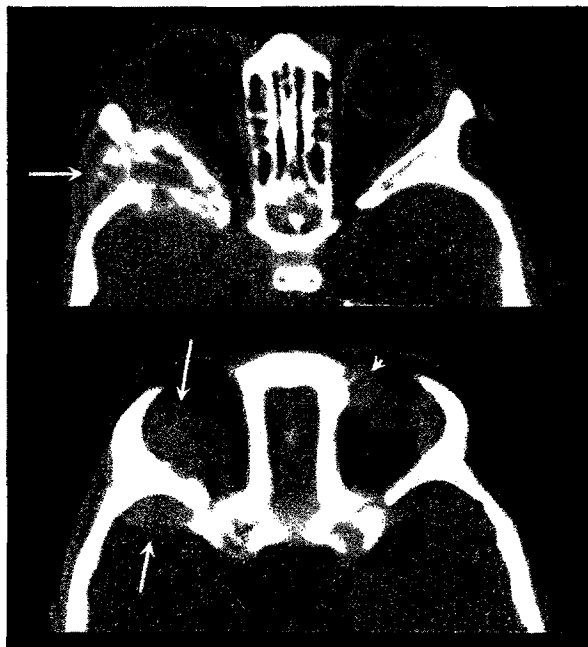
Images obtained from an 18-month-old girl with periorbital and facial ecchymoses in ER, evaluated for NAI. Computed tomographic image shows bilateral iso-high-density orbital soft tissue masses with bone destruction (arrows) and extension into the right-side middle cranial fossa (diagnosis, neuroblastoma).
